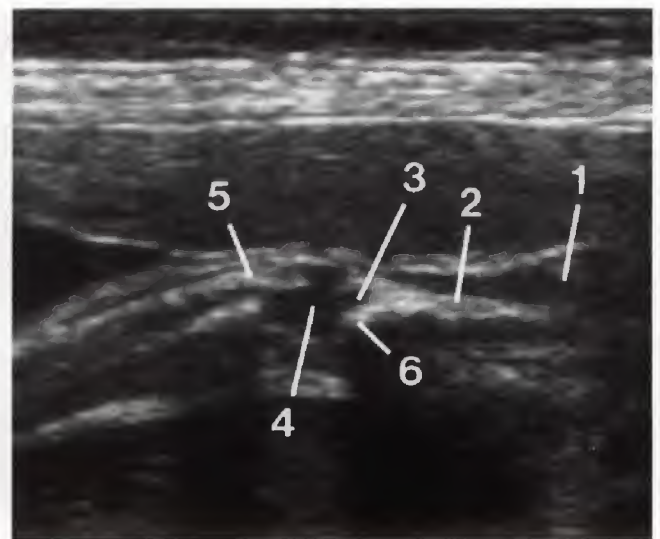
A and B. Parasagittal sonograms of the scapula. 1, infraspinous fossa; 2, infraspinatus muscle; 3, scapular spine; 4, supraspinatus muscle; 5, supraspinous fossa; 6, subscapularis muscle; 7, ribs in short axis.
